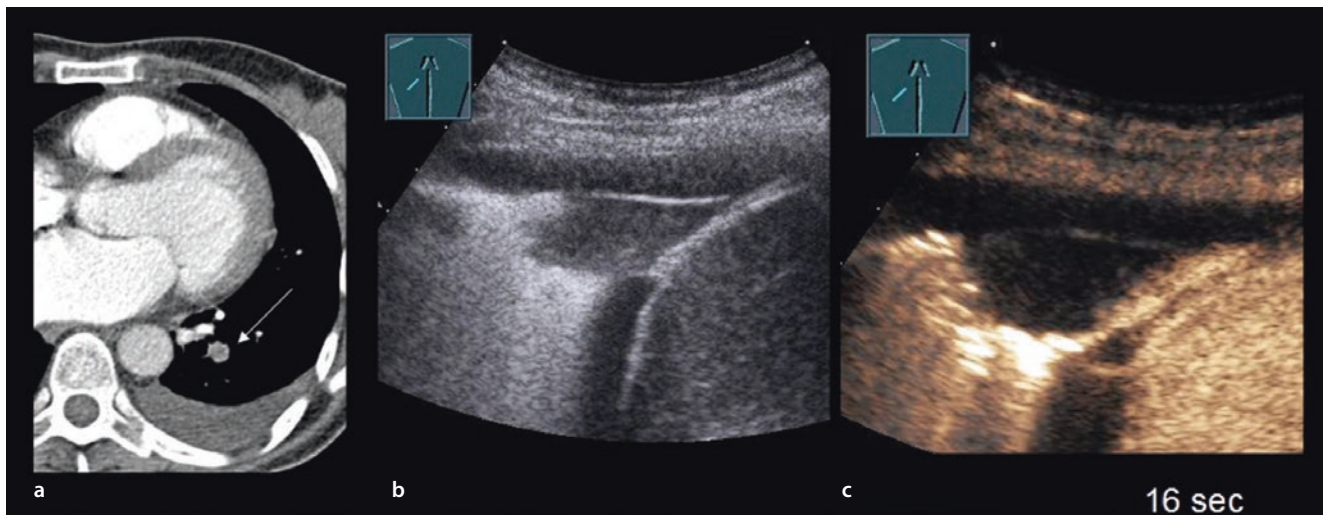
a Woman with pulmonary embolism confirmed on computed tomography. b B-mode ultrasonography reveals a wedge-shaped, uniformly hypoechoic pulmonary consolidation with smooth margins. c The contrasted investigation shows no enhancement of the lesion
